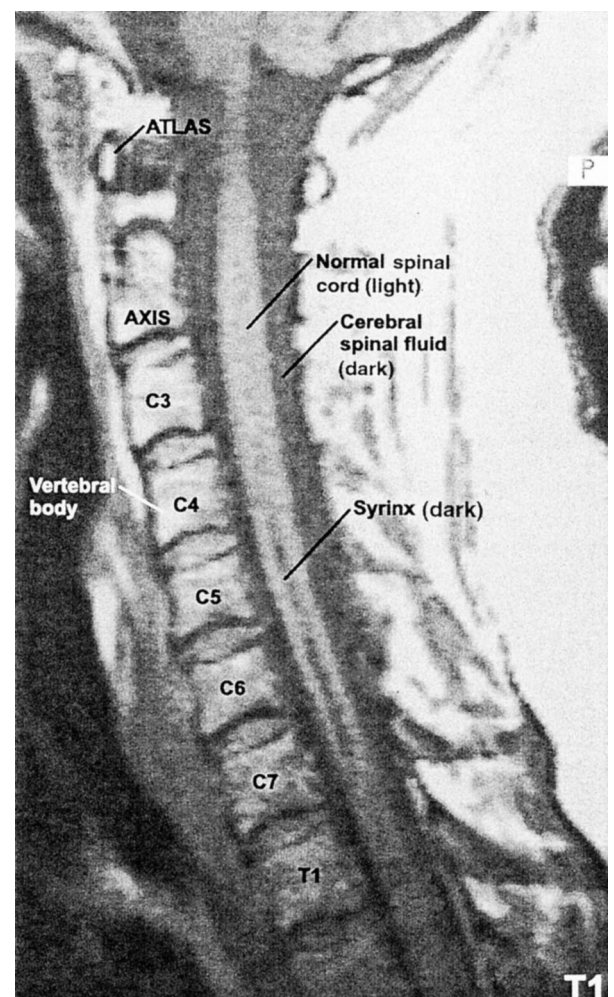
Scan of the T1-weighted sagittal section of the cervical spinal cord magnetic resonance imaging performed 9 months post-interscalene block in patient 1 showing a syrinx or cavity in the central portion of the right half of the C4–C7 spinal cord.
